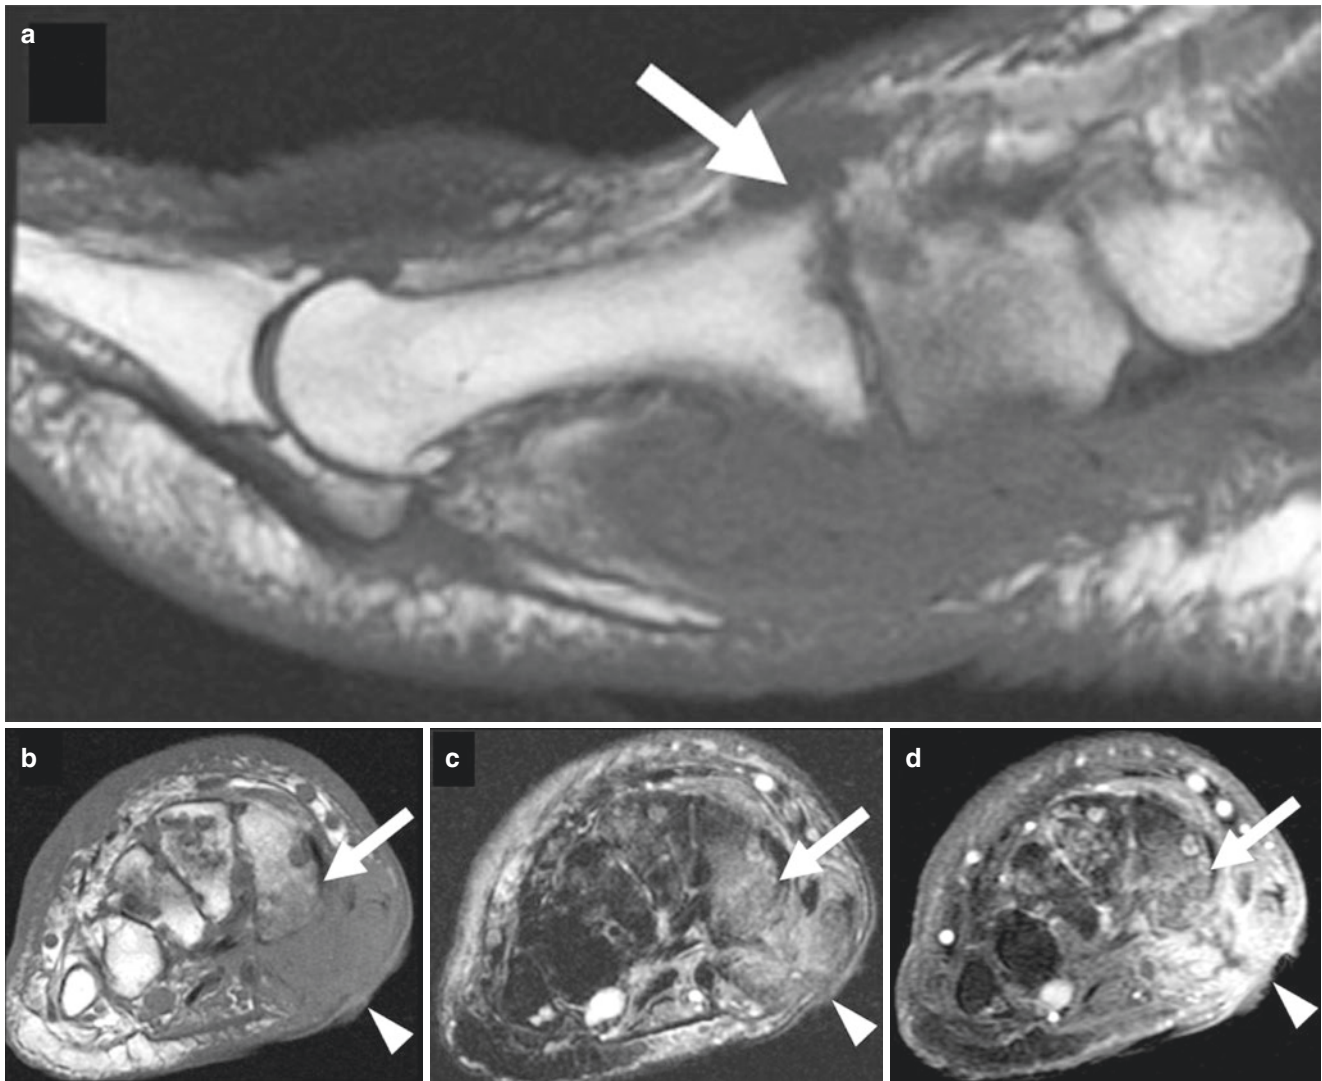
A 56-year-old man with neuropathic osteoarthropathy of the midfoot presents with an ulceration and concern for superimposed osteomyelitis. Sagittal T1-weighted image (a) shows Charcot arthropathy involving the Lisfranc joint (arrow). Coronal T1-weighted (b), T2-weighted fat-suppressed (c), and T1-weighted fat-suppressed
